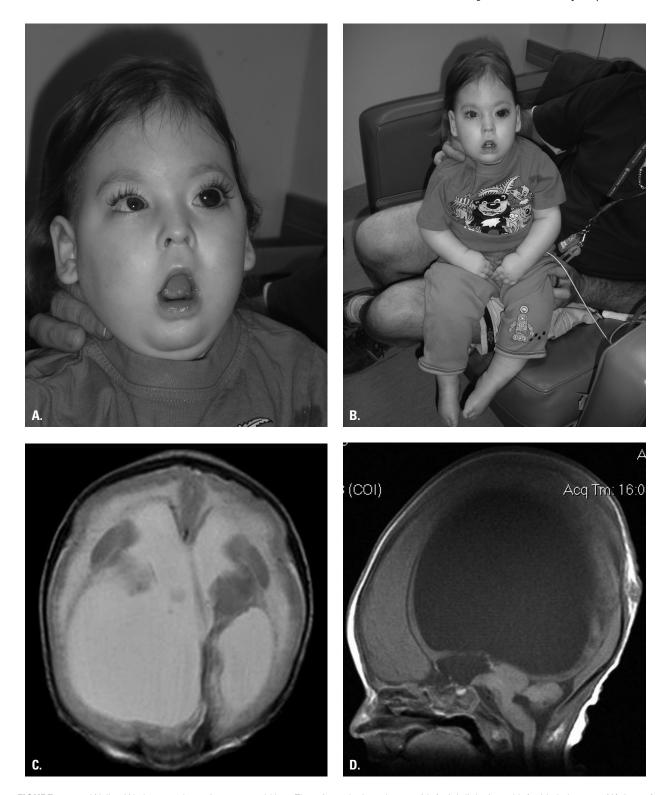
Walker-Warburg syndrome in a 2-year-old boy. There is marked weakness with facial diplegia and left-sided glaucoma (A), loss of muscle bulk and distal contractures (B). On brain magnetic resonance imaging (axial T_2 - and sagittal T_1 -weighted images [C, D]), there is severe hydrocephalus and cobblestone lissencephaly (MR images courtesy of Dr Rick Leventer).
